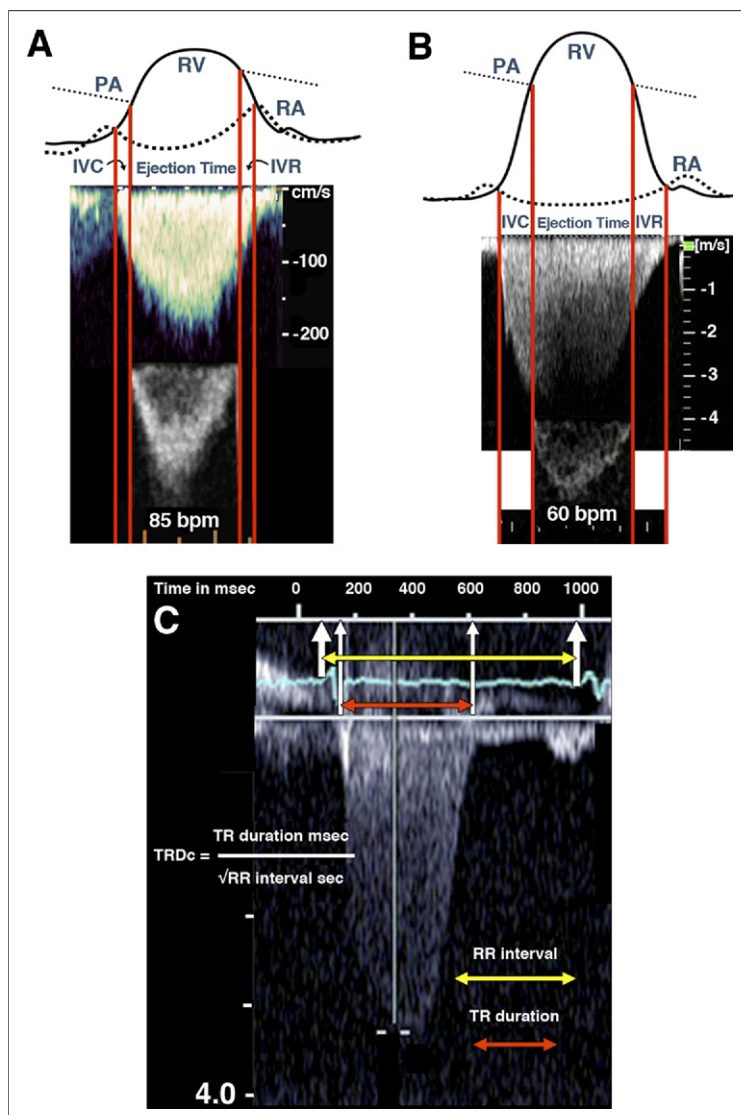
Duration of the TR Signal on Continuous-Wave Doppler
